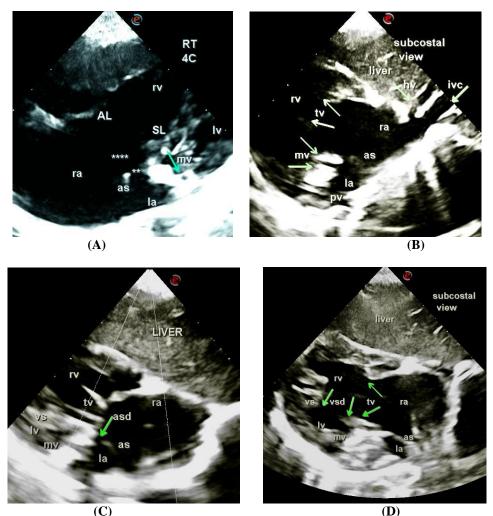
Complete AV canal defect. The apical 4C view from the right chest and subcostal view delineates CAVCD with large ASD and VSD. Dilated RV and small LV. Large TV leaflets and hypoplastic MV annulus was also recognized. AL, anterior leaflet; SL, septal leaflet; , CAVCD; , ostium primum ASD; hv, hepatic vein; ivc, inferior vena cava; la, left atrium, lv, left ventricle; ra, right atrium; rv, right ventricle; as, atrial septum; vs, ventricular septum; tv, tricuspid valve; mv, mitral valve.
